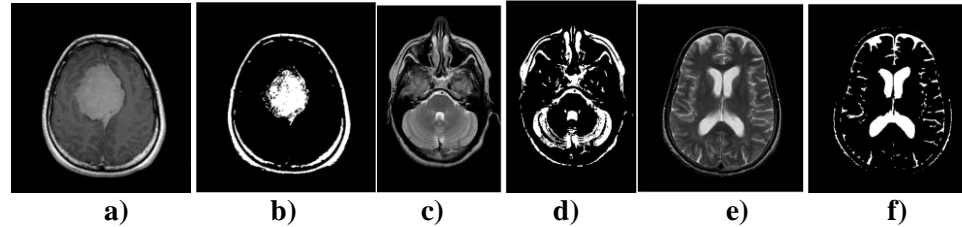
20 Otsu's algorithm applied to MRI slice. a) original image, b) thresholded image, c) original image, d) thresholded image, e) original image, f) thresholded image.
